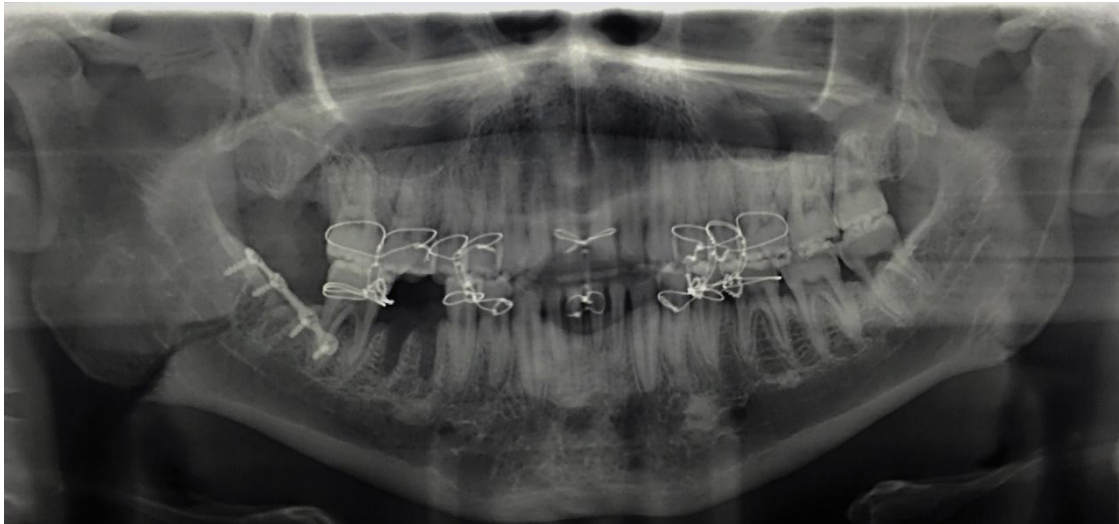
A preoperative panoramic radiograph of patient 3 showing a right mandibular angle fracture.
